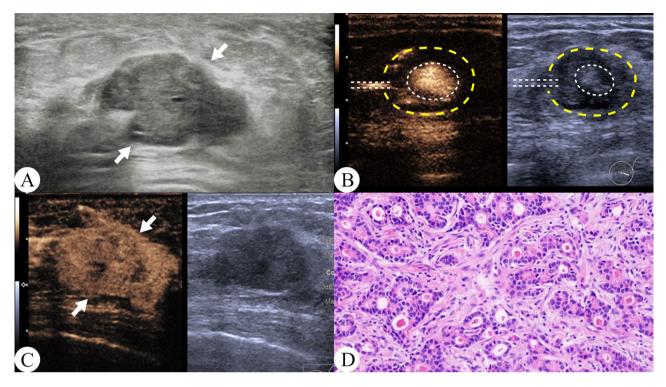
A patient presented with serous discharge from the left breast for two days. A Breast ultrasound revealed a hypoechoic nodule at the 3 o'clock position of the left breast. The relationship between this nodule and the duct was unclear. B USG revealed twisted ductal structures with lesions infiltrating outward along the ducts. C CEUS showed the nodule exhibiting heterogeneous hyper-enhancement and an enlarged enhancement scope (arrow). D Pathology identified the lesion as an invasive ductal carcinoma
